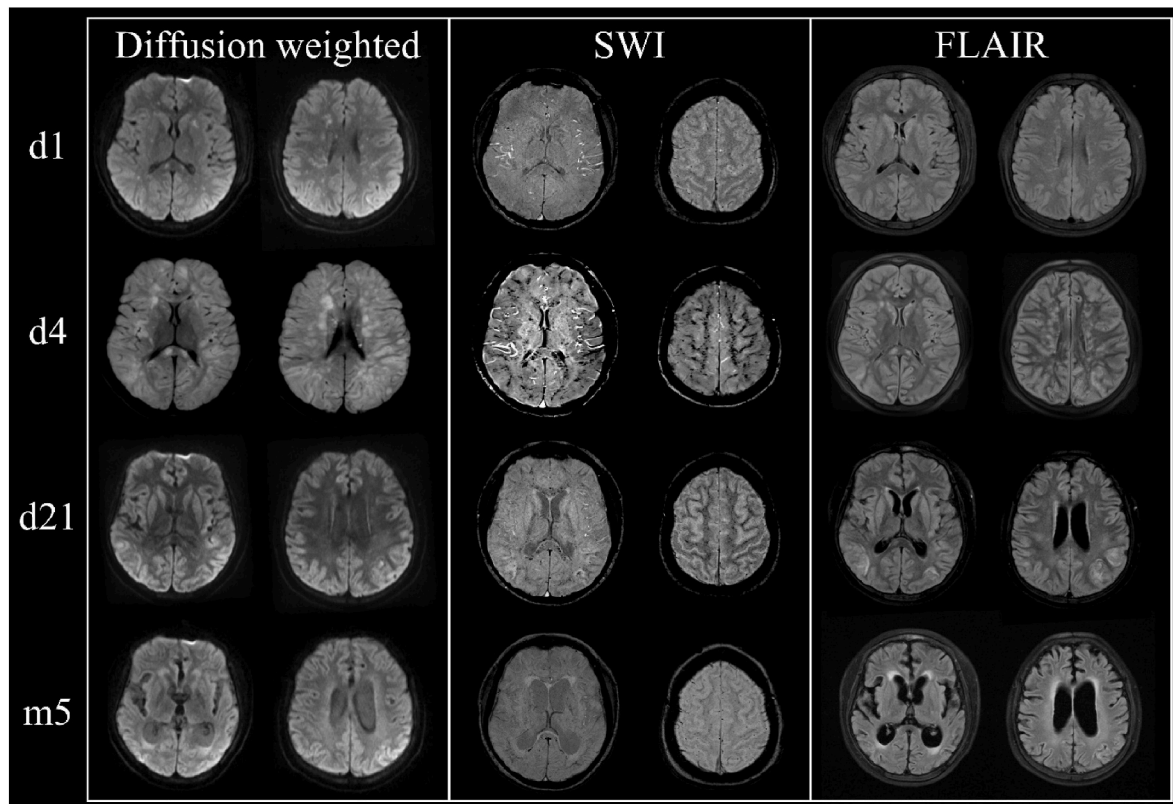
Cranial MRI one day post-surgery reveals multiple, dot-shaped diffusion restrictions and on susceptibility weighted imaging (SWI) signal extinctions in the inner border zone and basal ganglia (d1). Follow-up MRIs on day 4 and 21 (d4 and d21) are indicative of cytotoxic cerebral oedema with focal diffusion-restricted lesions as well as microbleedings with typical “walnut kernel” sign (SWI, maximum on d4). MRI on day 21 and at 5 months (m5) show progressive global atrophy and periventricular gliosis (FLAIR). SWI susceptibility weighted imaging, FLAIR Fluid-attenuated inversion recovery.
